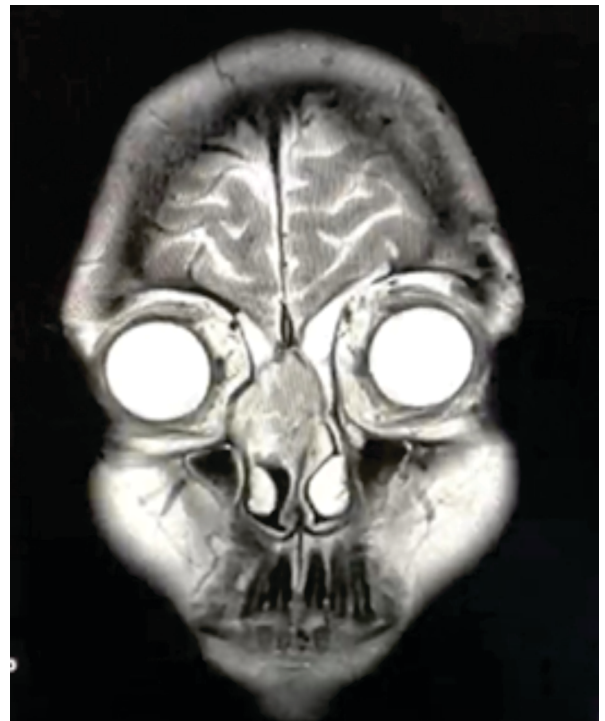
Computed Tomography Scan: Rounded, Homogeneous, Soft Tissue Mass Over the Right Middle Meatus, Causing a Partial Obstruction and Pushing the Nasal Septum
